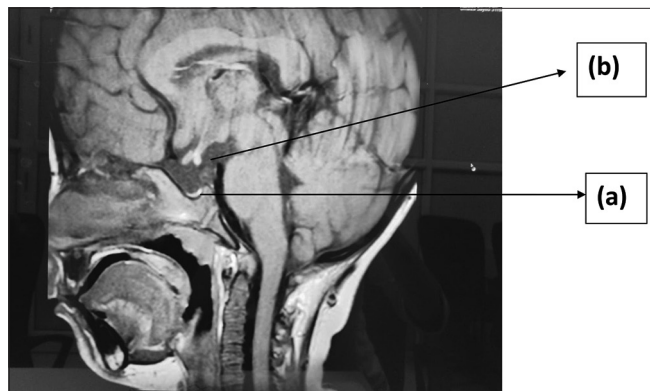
Magnetic resonance imaging pituitary showing: (a) Small anterior pituitary, (b) Ectopic posterior pituitary bright spot.
